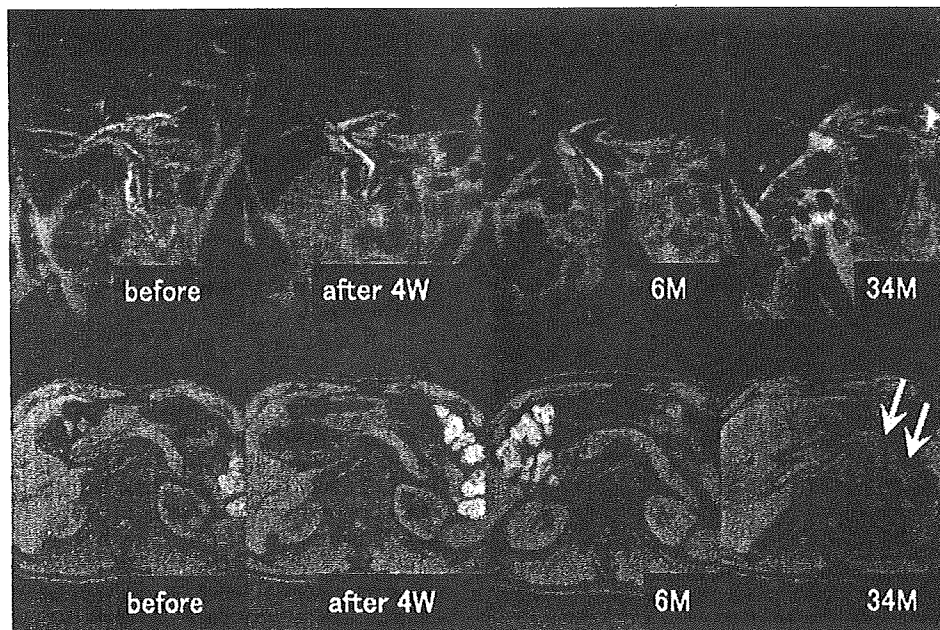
Bile duct lesions in a 69-year-old man. Oblique coronal T2-weighted images (upper column) before and after corticosteroid therapy images show gradual improvement of the bile duct lesion. Thirty-four months after corticosteroid therapy, the bile duct lesion had relapsed. Axial fat saturated T1-weighted images (lower column) show a new pancreatic lesion (white arrows) accompanied by relapsed bile duct lesion.
